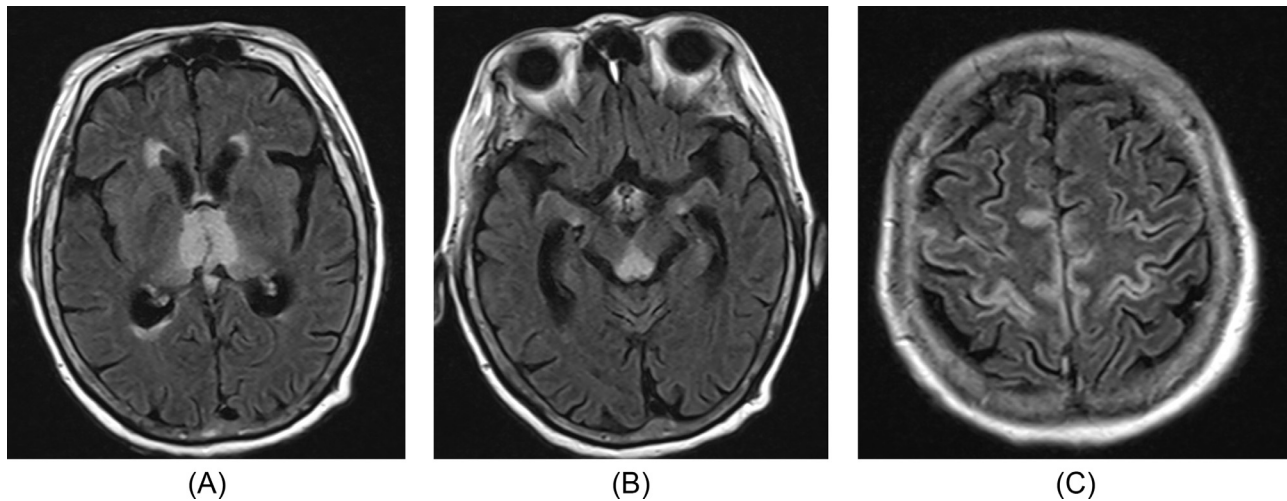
MRI of a 60-year-old woman with a history of depression for over 20 years who was admitted to the hospital complaining of altered consciousness. MRI identified fluid-attenuated inversion recovery (FLAIR) hyperintense signals in the thalamus (A), cerebral aqueduct (B), and cerebral cortex around the central sulcus (C).
